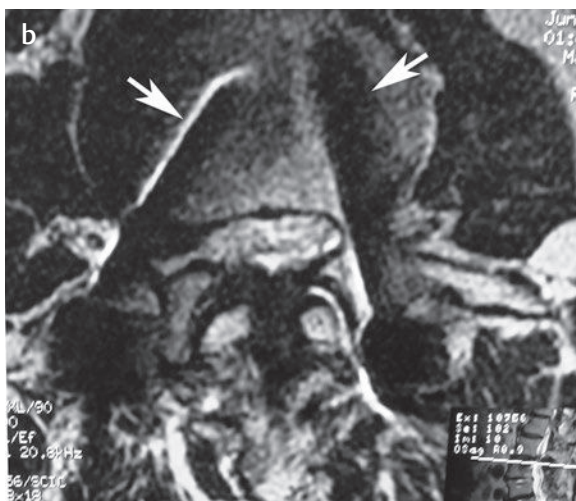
Junctional lumbar stenosis above instrumented fusion. (a) A sagittal T2-weighted image shows junctional stenosis (*arrow*) at the L2-L3 level in a patient who has undergone L3-L5 laminectomy and instrumented fusion. Note the minimal artifact from the pedicle screws (*arrowheads*). (b) An axial T2-weighted image at the L3 pedicle screw level shows moderate to severe stenosis and also shows the pedicle screws (*arrows*). Note that the presence of the pedicle screws obscures the region of the lateral recess and foramen but does not prevent the evaluation of the status of the central canal. (c) An axial T2-weighted image at the L2-L3 level shows severe stenosis and only minimal residual artifact (*arrow*) from the pedicle screw below this level in the L3 vertebral body. Note the localizing sagittal image seen as an inset with each axial image (b, c).[†]
